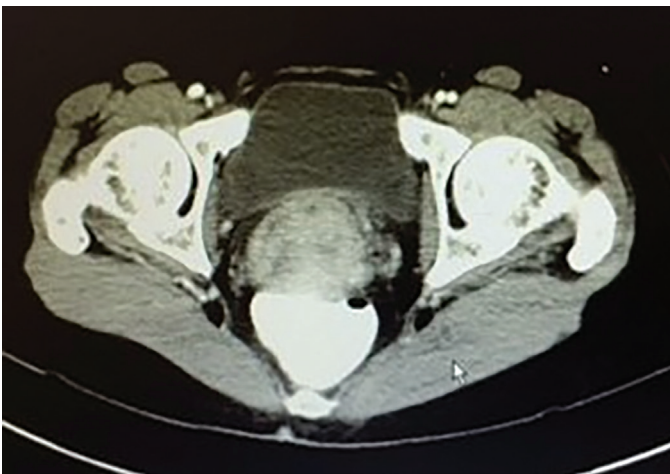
Contrast-enhanced lower abdomen CT scan abdomen revealed a mass in the cervix with obliteration of the fatty planes between the mass and the rectum posteriorly
